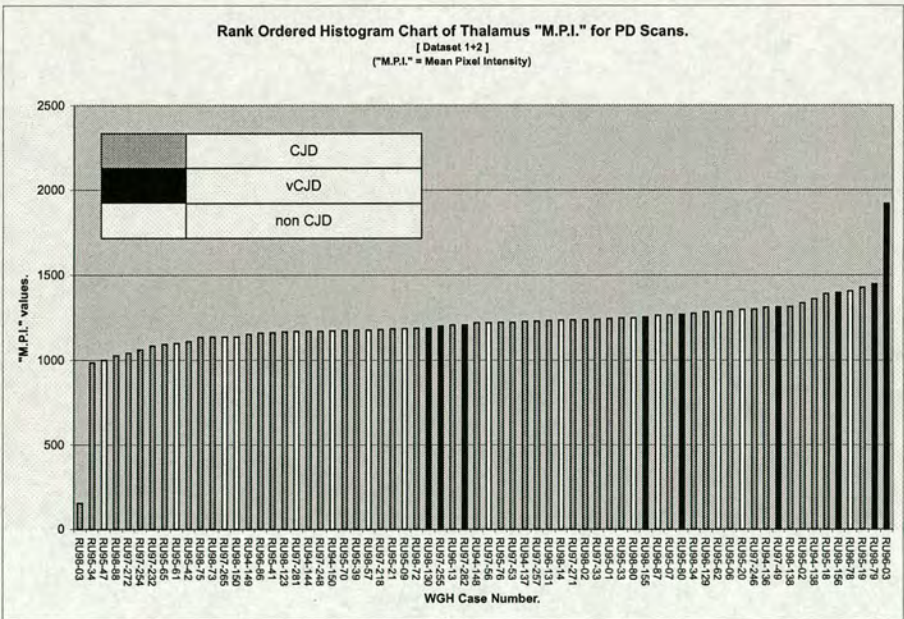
Thalamus Tests: Rank ordered histogram of the Thalamus region "M.P.I." values for the PD weighted MRI scan-data from datasets 1 & 2 combined.
